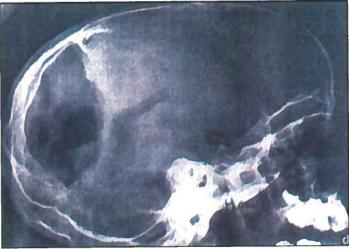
(b) X-rays showing growing fracture skull
